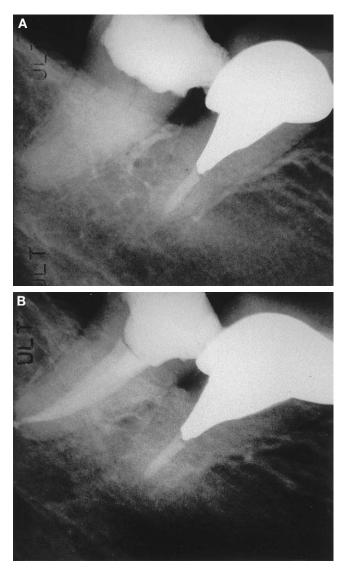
Tooth No. 31 with C-shaped canal. (A) Preoperative radiograph. (B) Postoperative radiograph.
